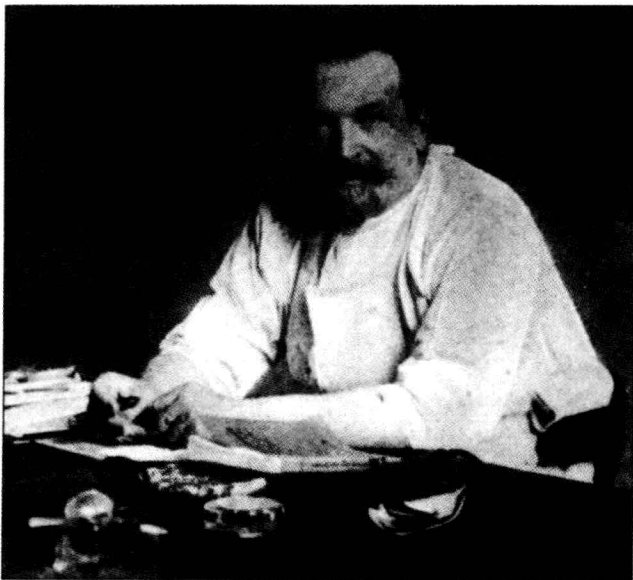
Etienne Destot, pioneer in combining studies of wrist anatomy, clinical conditions, and radiographic interpretations in a comprehensive fashion at the dawn of the roentgenographic era. Note radiation deformities of his fingers. (From Gallois E, Aigrot G, Japiot P. Etienne Destot [obituary]. *Lyon Chir.* 1919;16:8–134.)
